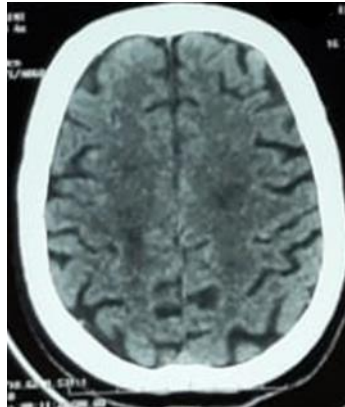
Axial brain CT scan showing lacunar lesions in the centrum semiovale
